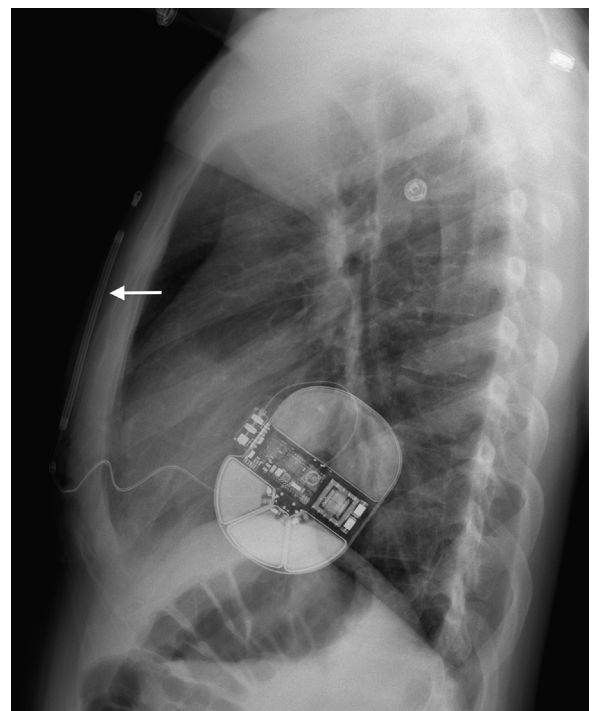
Lateral chest radiograph of a subcutaneous implantable cardioverter defibrillator system. Note that the electrode is tunneled into position anterior to the manubrium (arrow).
